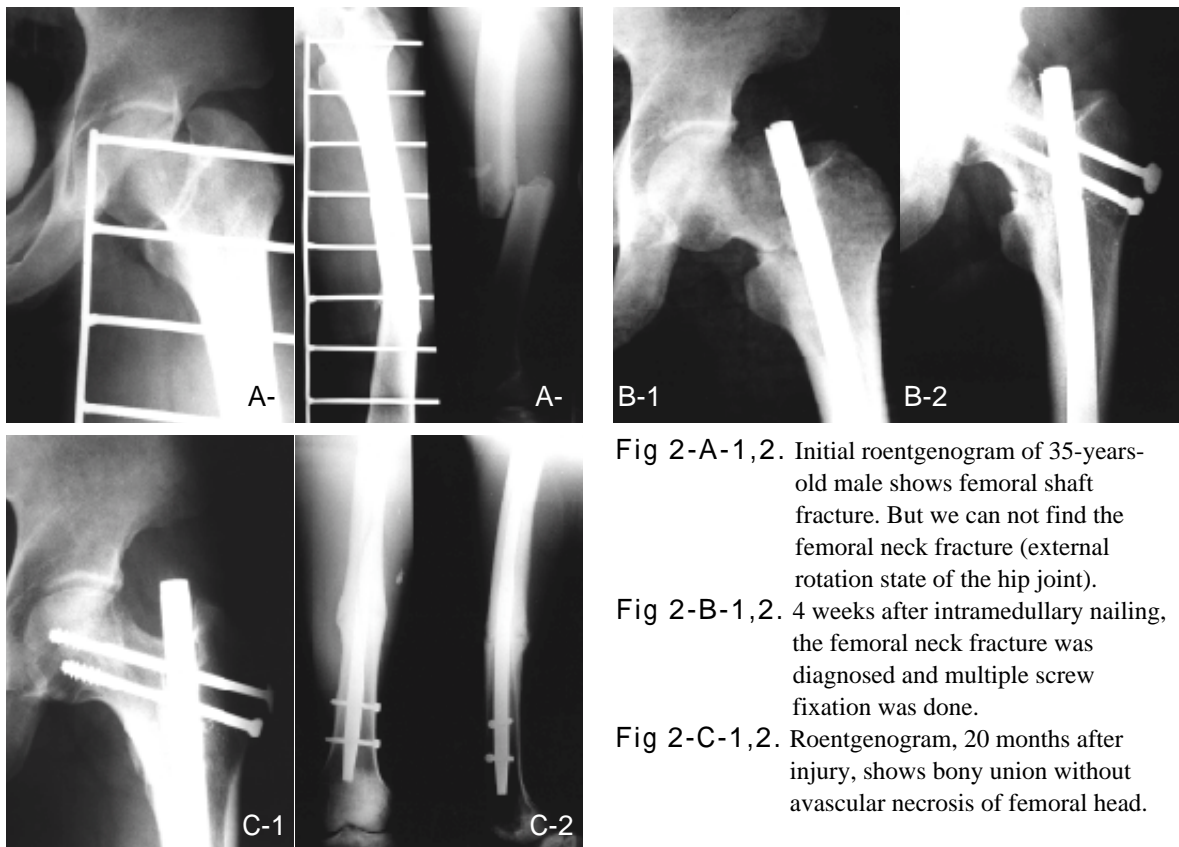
Initial roentgenogram of 35-years-old male shows femoral shaft fracture. But we can not find the femoral neck fracture (external rotation state of the hip joint).
